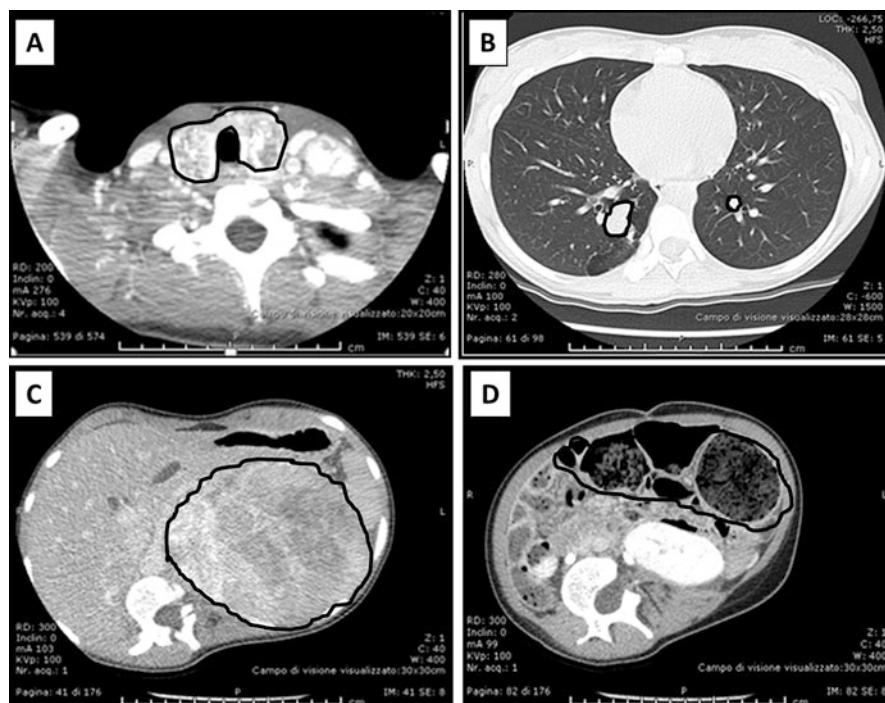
CT scans with contrast medium of a multiple endocrine neoplasia 2B patient before surgery: (panel a) neck scan showing the bilateral involvement of the thyroid gland; (panel b) lung scan showing multiple and bilateral pulmonary metastases; (panel c) huge pheochromocytoma of the left adrenal gland; (panel d) severe and abnormal dilatation of the colon (i.e., megacolon) frequently present in MEN 2B patients
